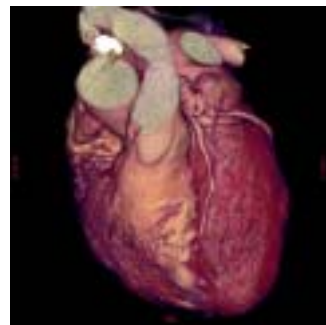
Coronary artery CT angiogram referred by cardiology.
